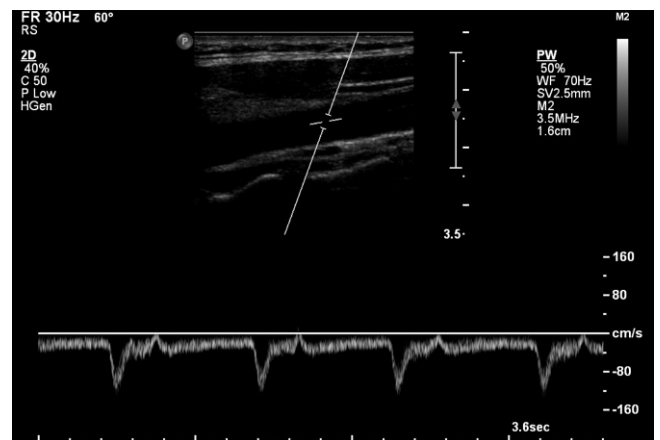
Spectral Doppler of common carotid artery with flow below the baseline indicating flow away from the transducer (not inverted as in Fig. S3-5) with flow toward the head.
